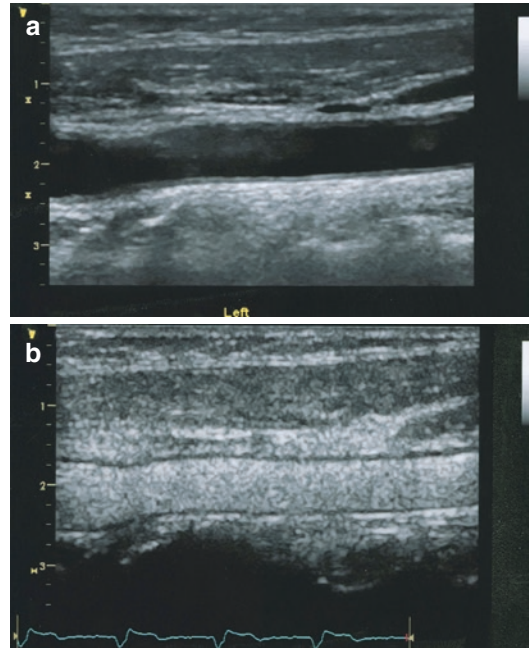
Unenhanced (a) and contrast-enhanced (b) ultrasound of the near wall of the carotid artery clearly delineating the carotid intima-media thickness. Feinstein [67]
